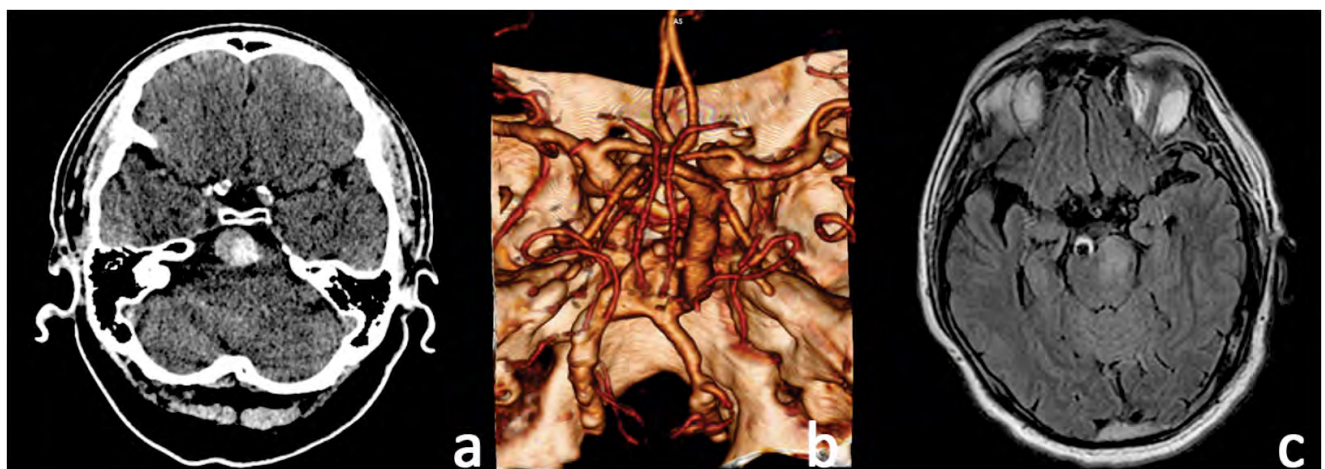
a. The brain CT scan – hyperdense, inhomogeneous prepontine lesion, situated in the area of BA. b. Angio-CT scan reveals a fusiform dilation (aneurysm), 18 mm diameter and 40 mm long, partially thrombosed of the BA, associated with a saccular aneurysmal dilation of the communicant segment of the left internal carotid artery, 7 mm in diameter. c. Brain MRI – pontine infarction
